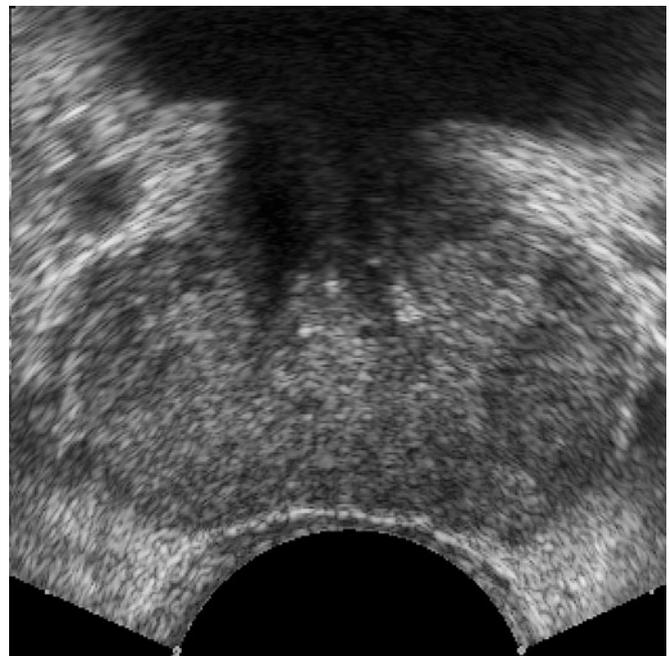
Grey-scale transrectal ultrasound of the prostate: the US image of the prostate does not show any suspicious lesions
